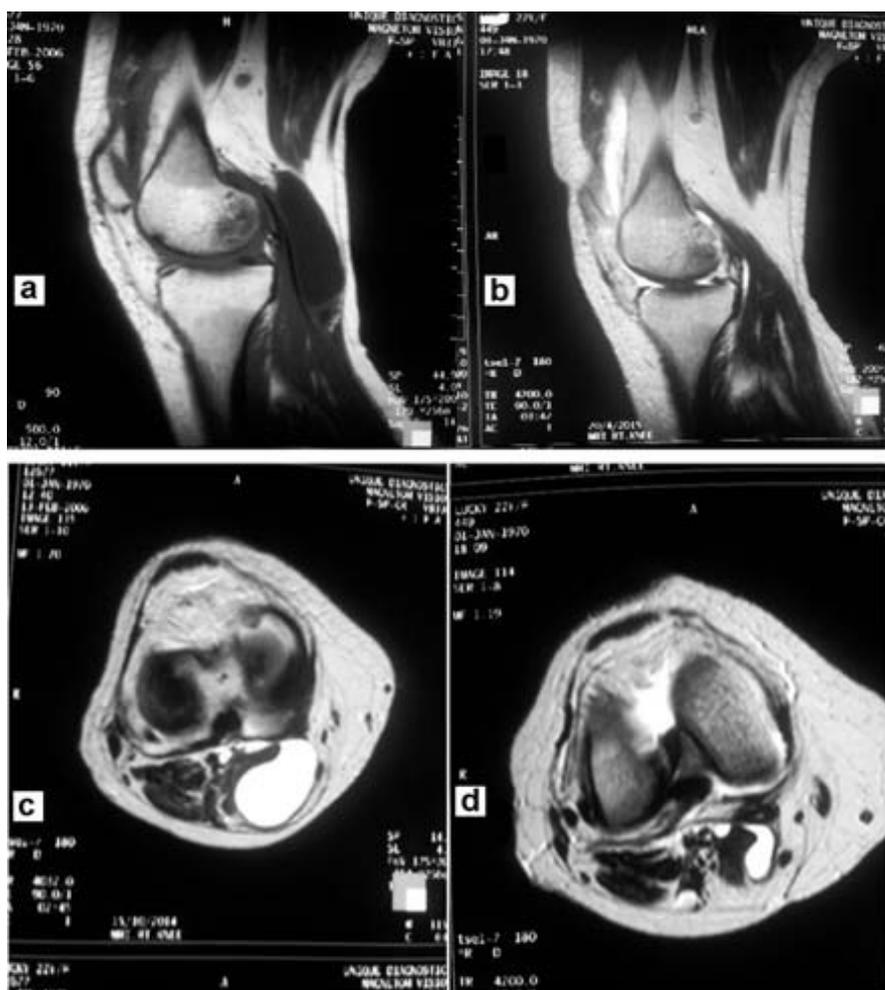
Comparison of pre- and post-operative MR images showing marked reduction in the size of cyst in both sagittal (a and b) and axial (c and d) sections.
